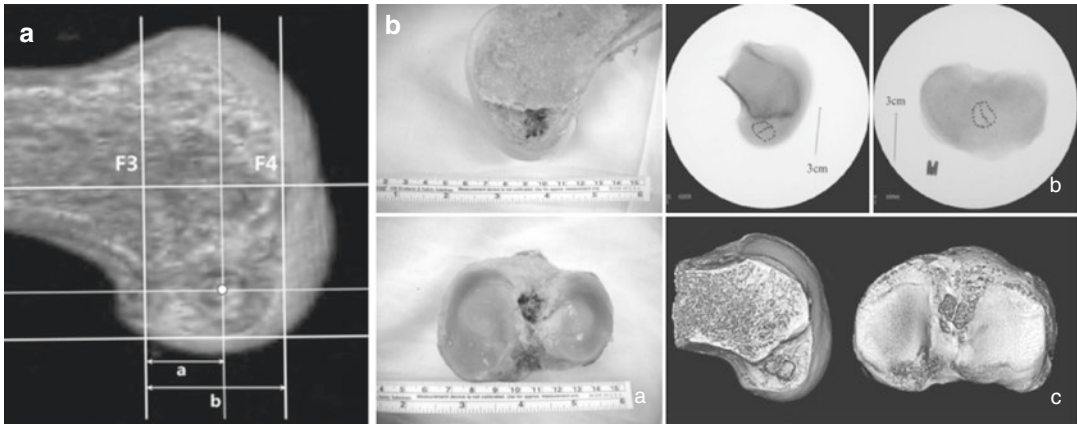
(a) A three-dimensional reconstructed CT image of the femoral tunnel aperture created with the modified TT technique (From [25] with permission). (b)
